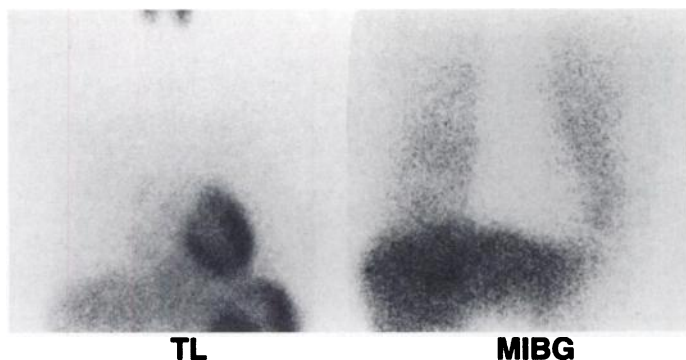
Thallium-201 scintigram (anterior view) shows normal distribution, but [^{123}I]MIBG scintigraphy (anterior view) shows none.
